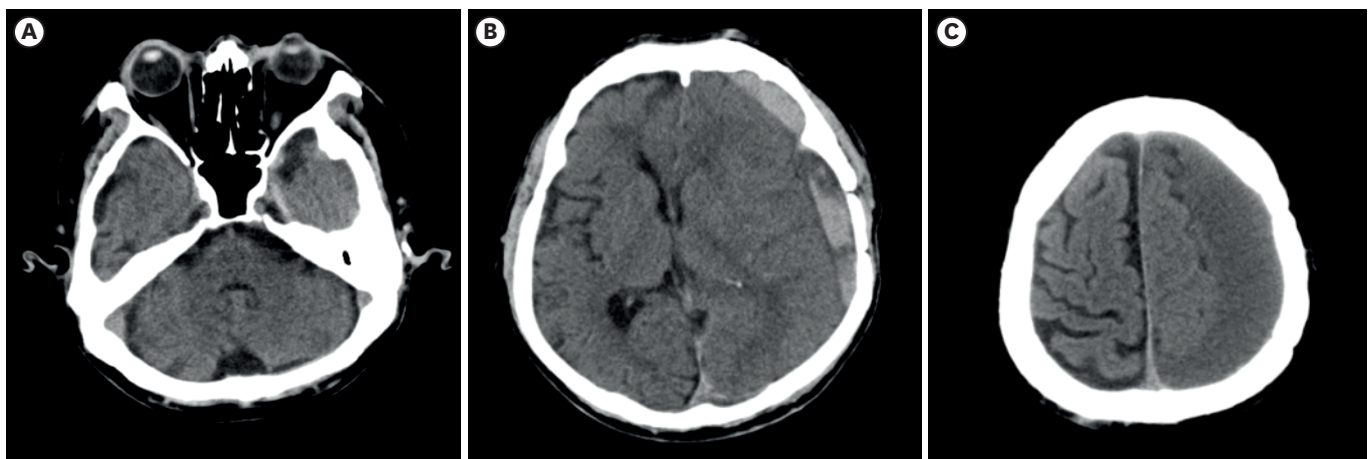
Brain CT scan at 3 weeks after discharge. (A) CT scan shows resolution of AEDH in the left cerebellum. (B) CT scan shows resolution of AEDH in the bilateral parietooccipital region, bifrontal cerebral contusion, ASDH and traumatic subarachnoid hemorrhage in the right frontal region. However, CT shows mixed density left SDH with midline shift of 8 mm. (C) CT scan shows CSDH with a maximum thickness of 30 mm in high frontal region. CT: computed tomography, AEDH: acute epidural hematoma, ASDH: acute subdural hematoma, SDH: subdural hematoma, CSDH: chronic subdural hematoma.
